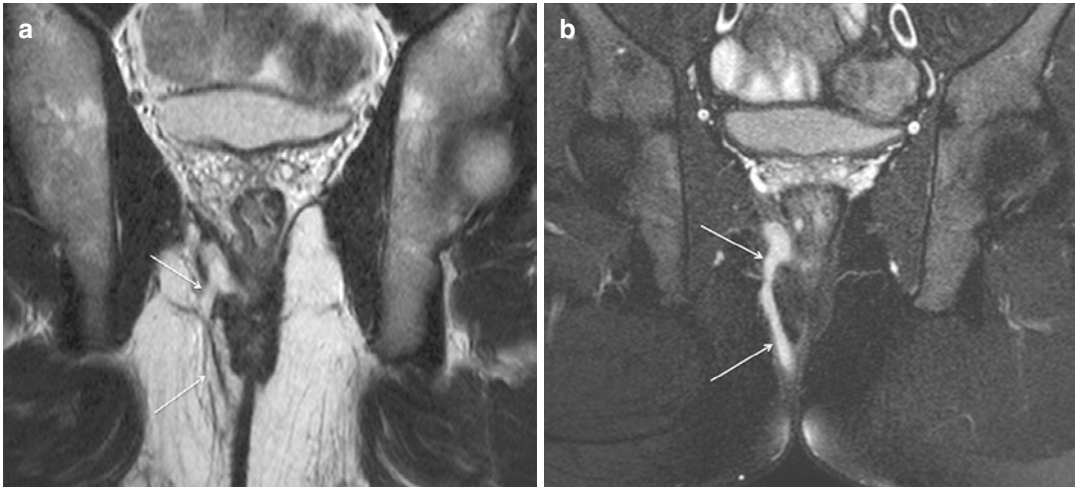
Trans-sphincteric fistula. Coronal-oblique T2-weighted TSE image (a) shows a right trans-sphincteric fistula, involving the ipsilateral ischioanal
